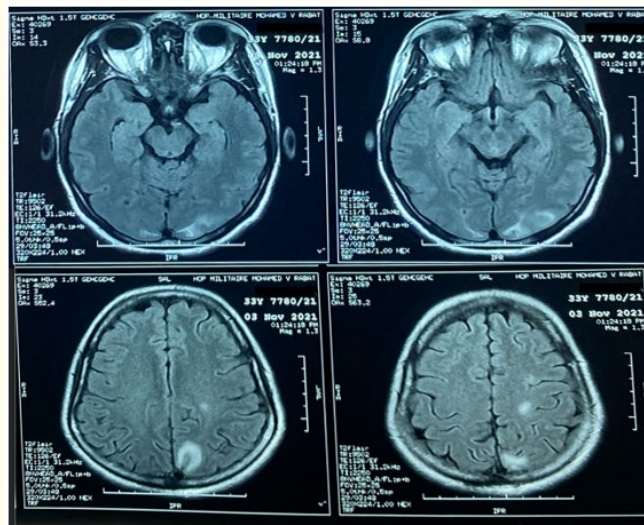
Bilateral occipital white matter T2/FLAIR high signal of the posterior junctional zone.
